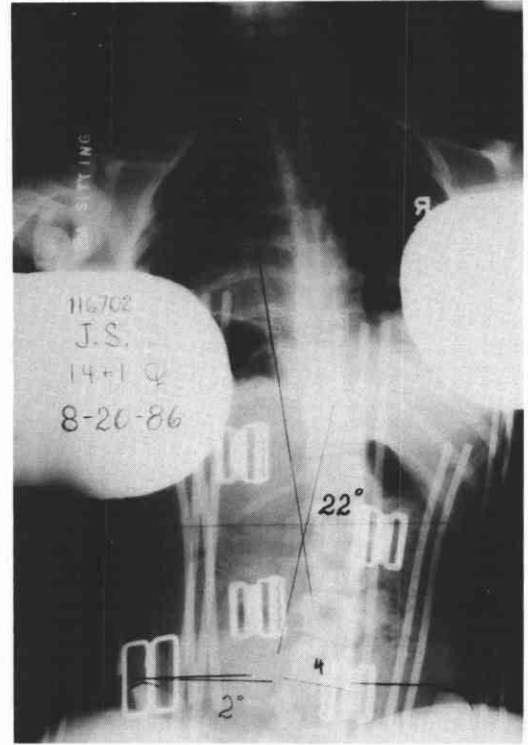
J.S. was provided with a sitting support system consisting of soft corset worn under her clothing and a somewhat abbreviated S.S.O. Her system was almost identical to that provided to S.T. (see Figure 10b). This x-ray shows a pelvic tilt reduced to 2°, the scoliosis curve reduced to 22°, and her shoulders level. She liked the system because her hands were free and she found breathing easier.
